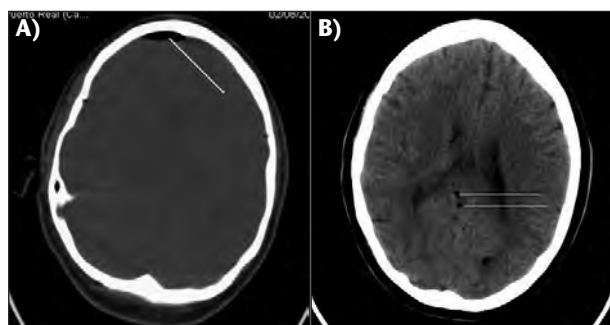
CT scan showing an air density image in the right frontal region (A, arrow) and other smaller ones, all intraparenchymal, located posterior to the splenium of the corpus callosum (B, arrows).
